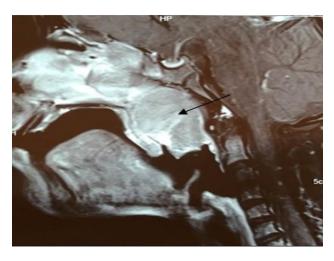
MRI-nasopharynx of a heterogeneously enhancing mass lesion (black arrow) in the posterosuperior wall of the nasopharynx.
